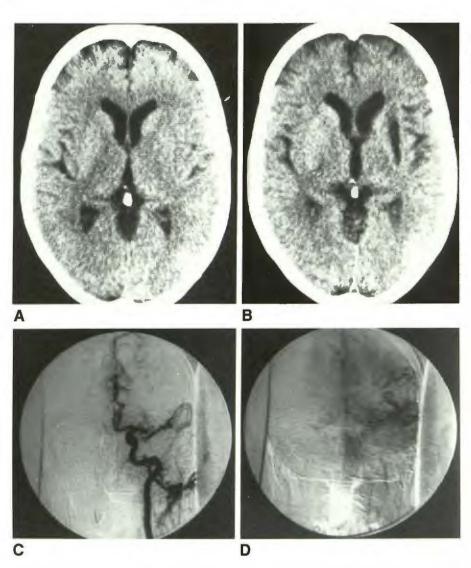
A, Early CT scan shows slight hypodensity of left putamen.
